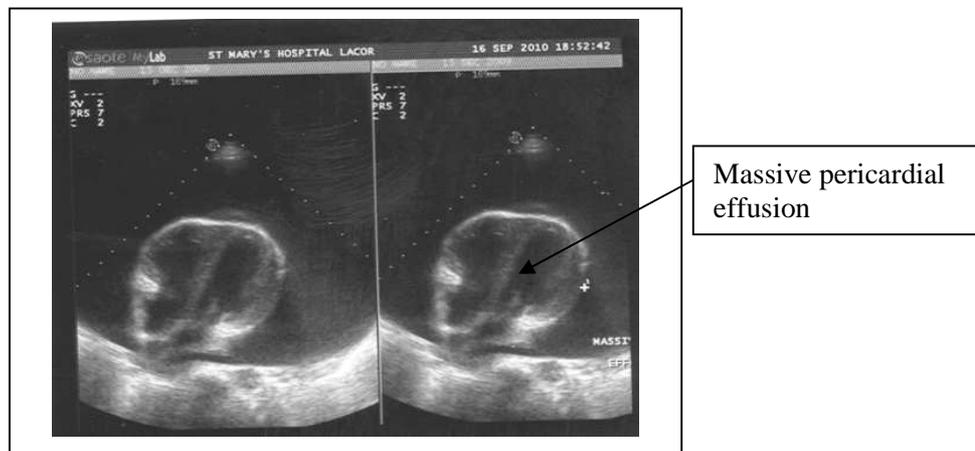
Echocardiography in a 12 year old HIV/AIDS patient: This sonography shows massive pericardial effusion measuring 7.5cm in thickness in a 12 year old female HIV/AIDS patient and with associated fine internal echoes and fibrin-like network and the pericardiocentesis was haemorrhagic. The finding confirmed TB pericarditis in this patient.
